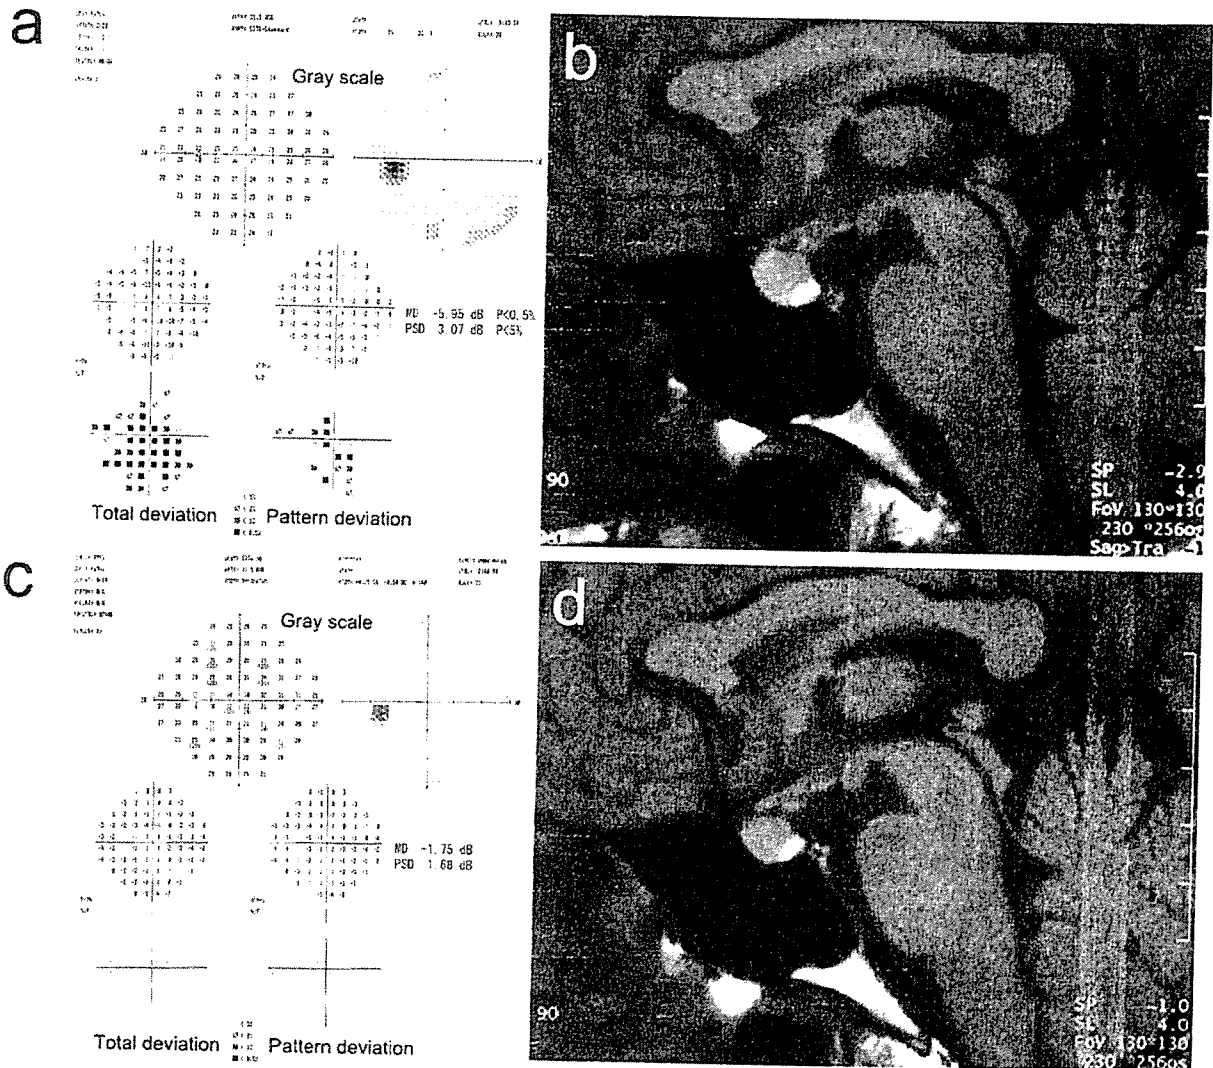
a Humphrey visual field testing of the left eye at 38 weeks of pregnancy shows a subtle reduction in central sensitivity. b Sagittal view of an MRI scan of the head at 38 weeks of pregnancy, showing pituitary enlargement, which is $12 \times 10 \times 11$ mm, homogeneous, and isointense, with compression of the anterior optic chiasm. c Humphrey
